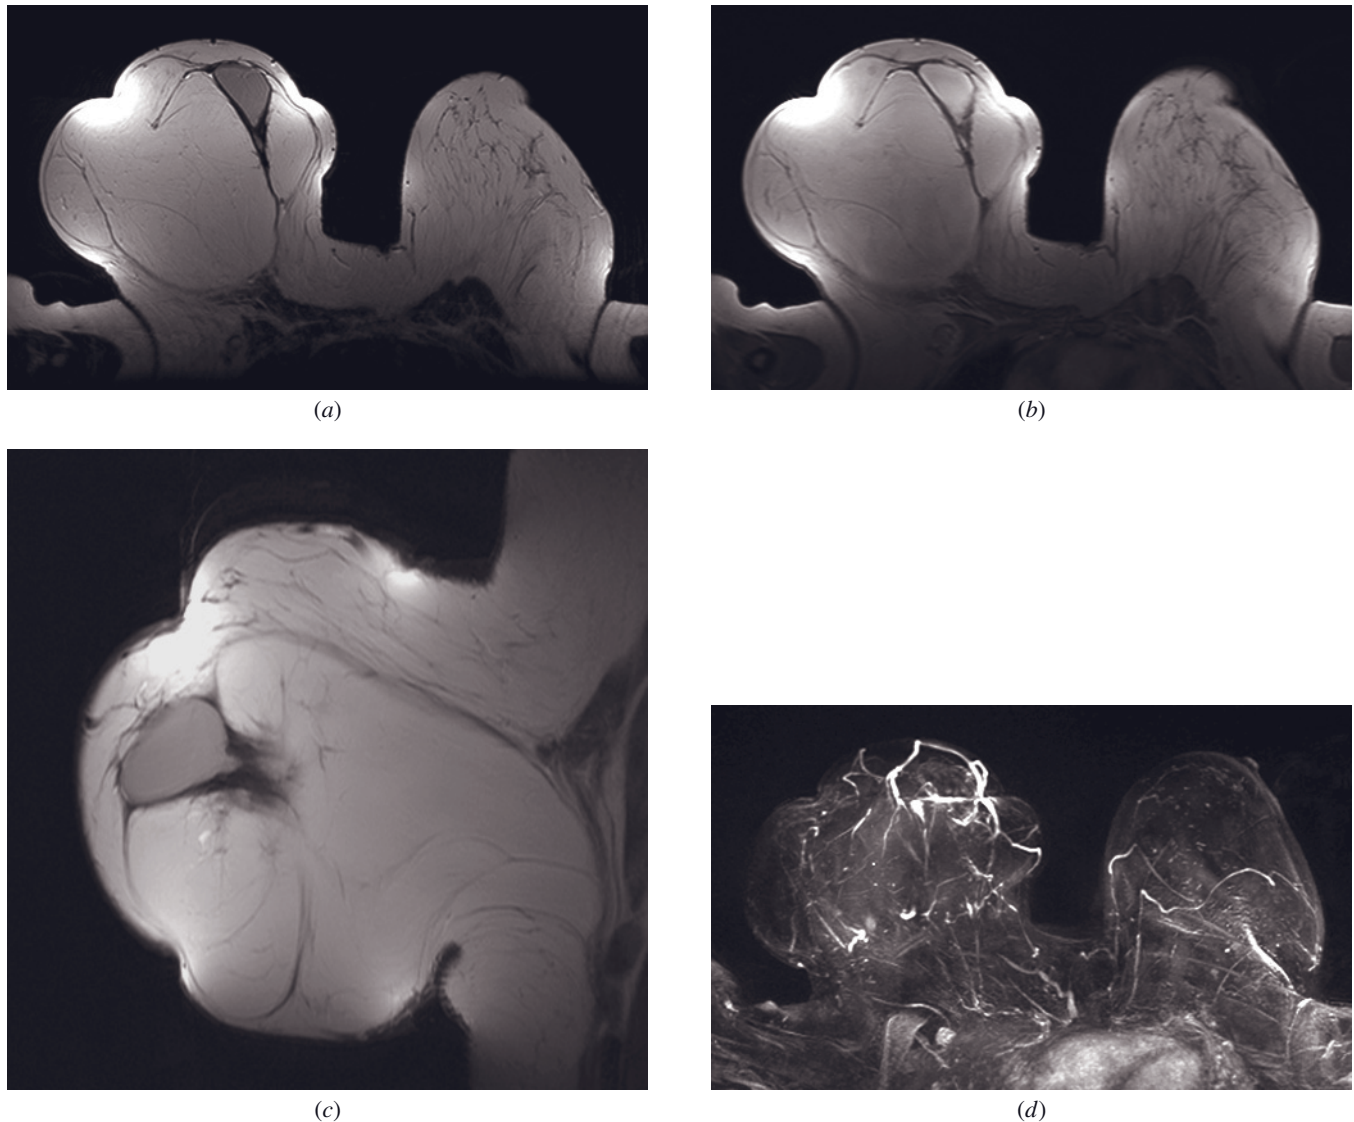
Lipoma and galactocoele. Axial T2-weighted (*a*) and T1-weighted (*b*) images reveal large (20 cm) encapsulated, homogeneous lipomatous tumor in the right breast that reaches the pectoral muscle without invasion, as shown on sagittal T2-weighted fat-saturated image (*c*). The well-circumscribed oval, T2 hypointense part of a tumor, measuring about 5 cm in diameter, shows high signal intensity on T1-weighted axial image (*b*) and no contrast enhancement (*d*). Fine needle aspiration (FNA) revealed galactocoele (patient presented 2 years after breast-feeding cessation).
